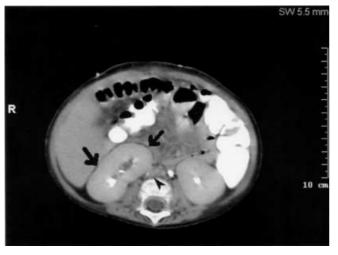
A 7-month-old girl with ACS after surgery for unreduced intussusception. CT performed a few hours before decompressive laparotomy shows displacement of the right kidney (*arrows*) with mild compression to the IVC (*arrowhead*)
